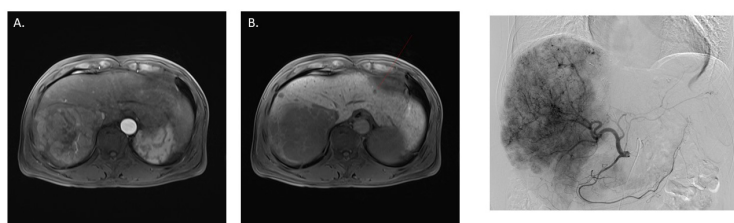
Initial liver magnetic resonance image findings. Right lobe dominant HCC with enhancement on arterial phase (A) and washout on portal phase (B).
